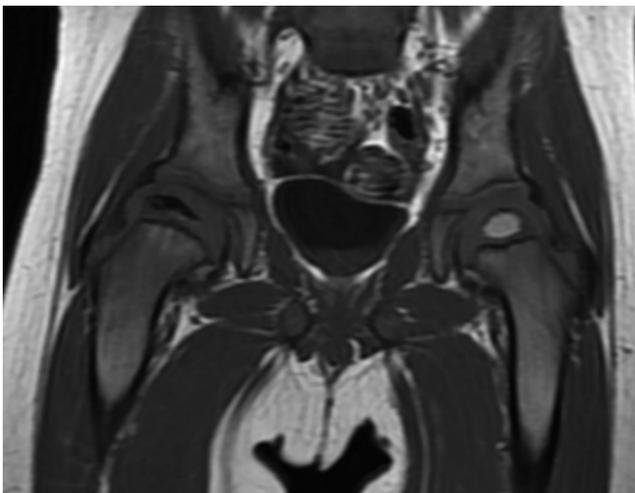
MRI at 9 months.
